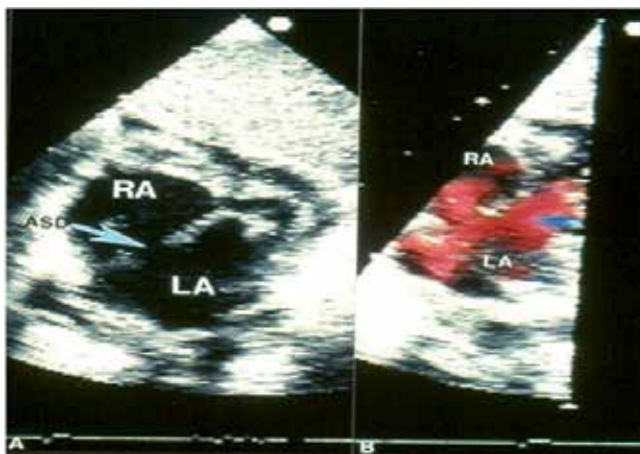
Two dimensional subcostal echocardiographic view of the atrial septum (A) demonstrating a secundum atrial septal defect (ASD) in the mid septum (arrow). Color Doppler imaging shows left-to-right shunt. LA, left atrium; RA, right atrium.
